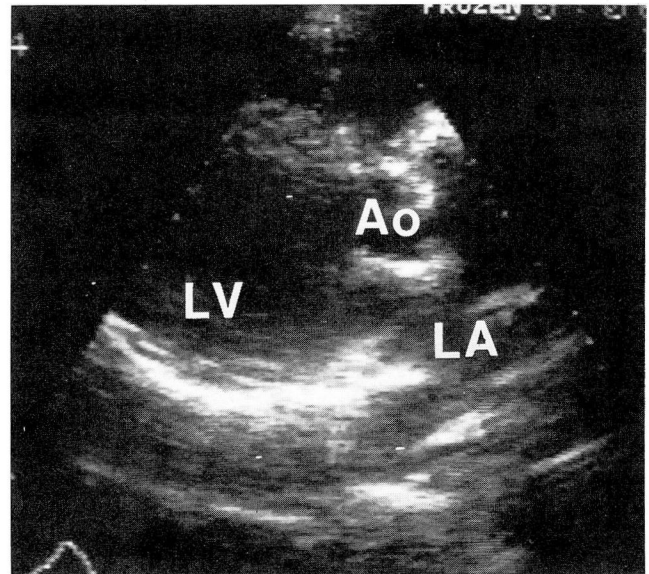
Postoperative two-dimensional echocardiogram, long axis parasternal view shows no evidence of mass in the right ventricular outflow tract above the aorta. (Ao = aorta; LV = left ventricle; LA = left atrium.)
